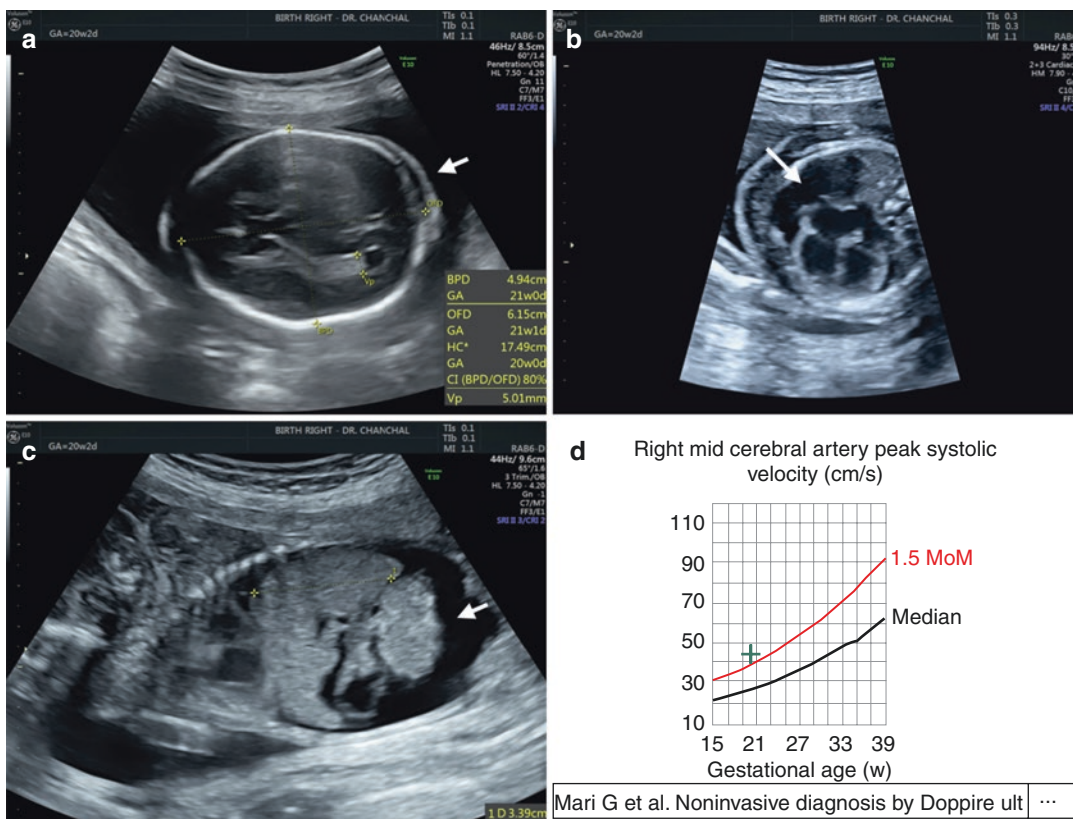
Fetal manifestations of HPV B19 infection: 2D ultrasound images showing subcutaneous edema (a), cardiomegaly and pericardial effusion (b), fetal ascites (c) and fetal MCA PSV above 1.5 MoM suggestive of fetal anemia (d)
